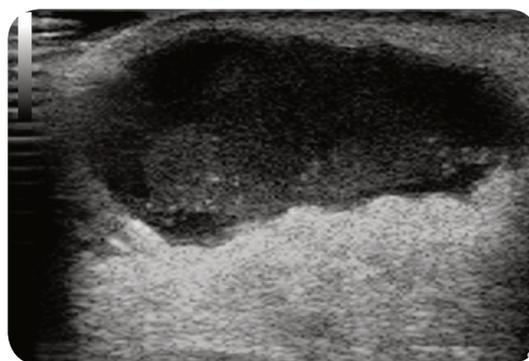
An ultrasound scan of the breast demonstrating a breast abscess, a complication of mastitis.
